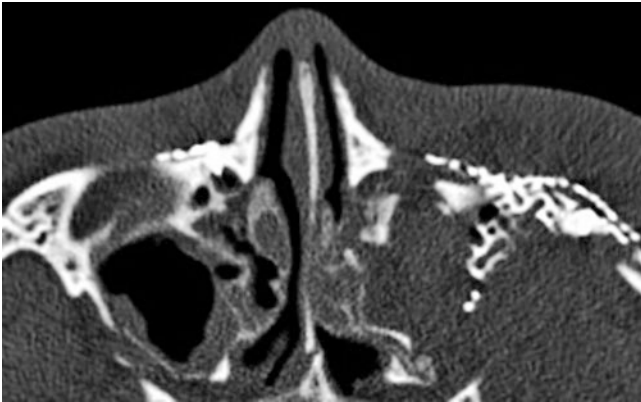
CT scan, axial cut, bony window, showing titanium screws near NLD
